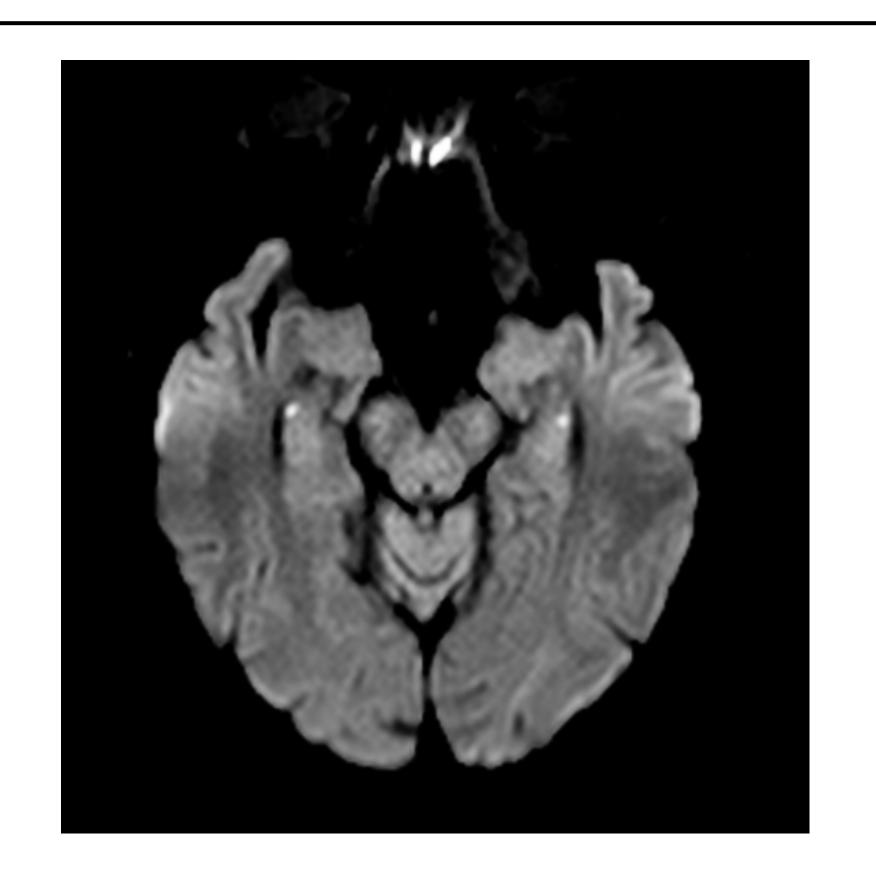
DWI with bilateral hippocampal hyperintensities. (https://radiopaedia.org/articles/transient-global-amnesia)
